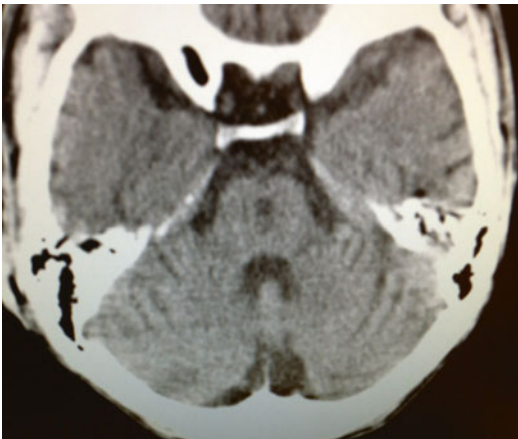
CT revealing old central pontine myelinolysis in a young alcoholic
